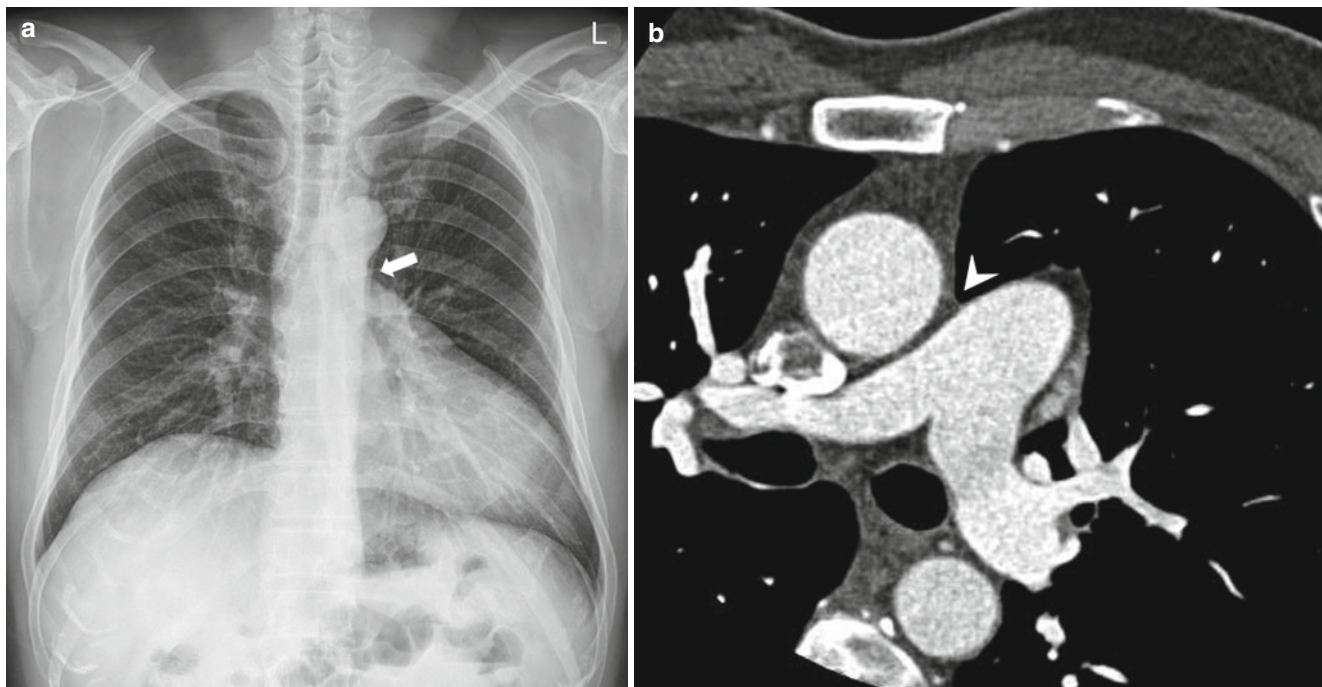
Chest radiographs and CT of a patient with partial pericardial defect. (a) Chest PA view. The heart is displaced into the left chest; the right border of the heart is projected over that of the spine. There is
